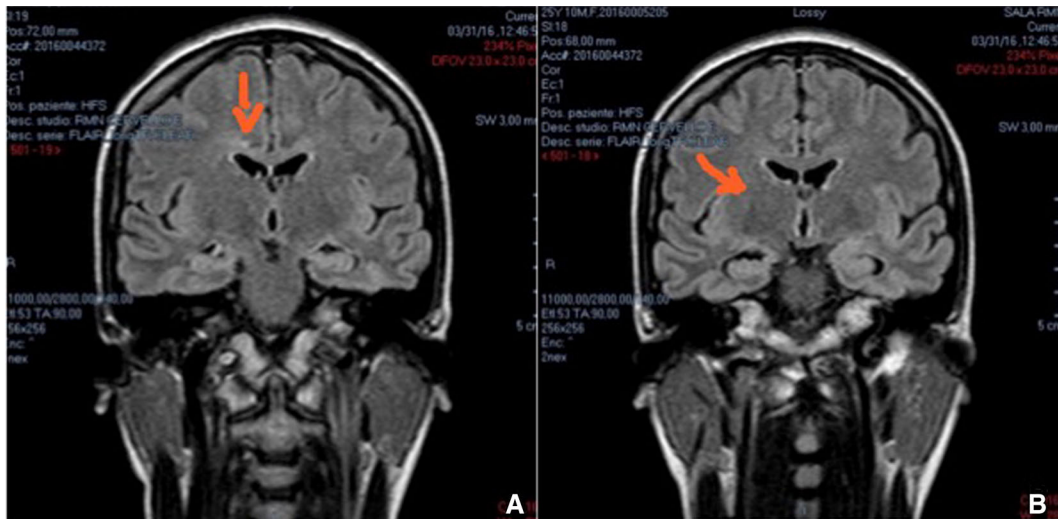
FLAIR-coronal sequences showing a small hyperintense acute inflammatory lesion in corpus callosum (right part) (a), and some small spots located in basal ganglia (b)
